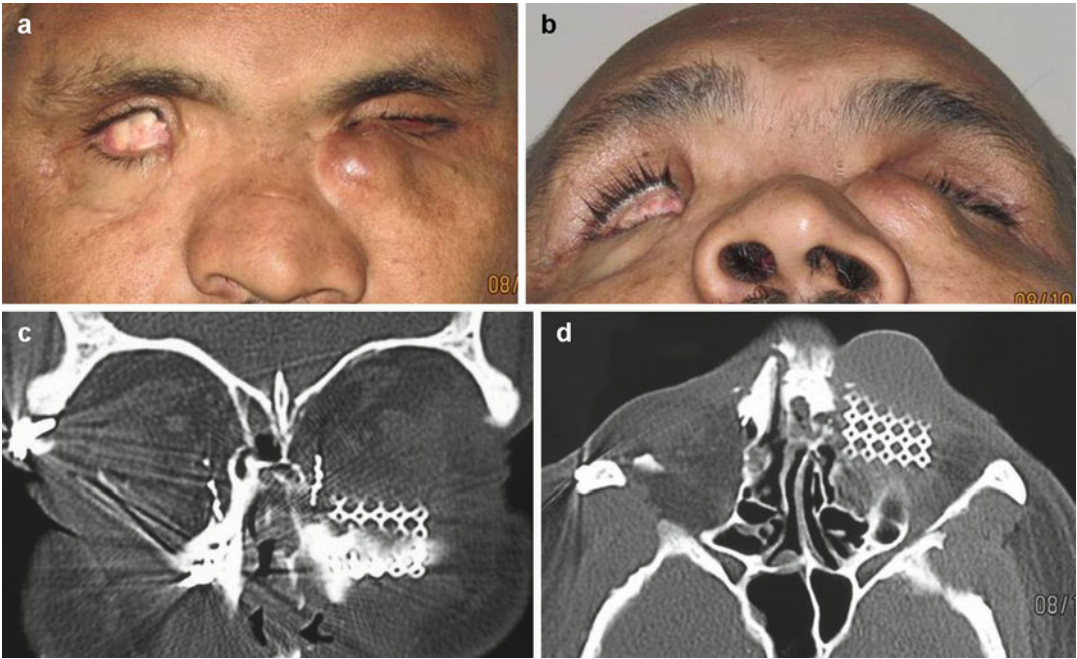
(a, b) external photographs showing left-sided traumatic NLDO with mucocele of lacrimal sac. Axial (c) and coronal (d) computed tomography scan showing left naso-orbito-ethmoidal fracture status post-primary repair in same patient
